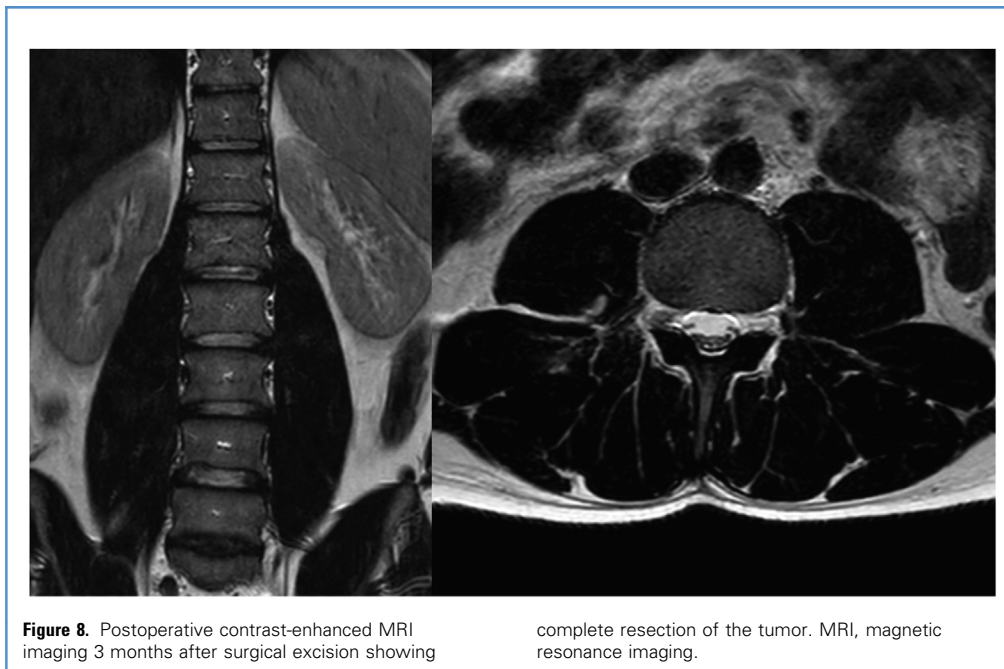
Postoperative contrast-enhanced MRI imaging 3 months after surgical excision showing
